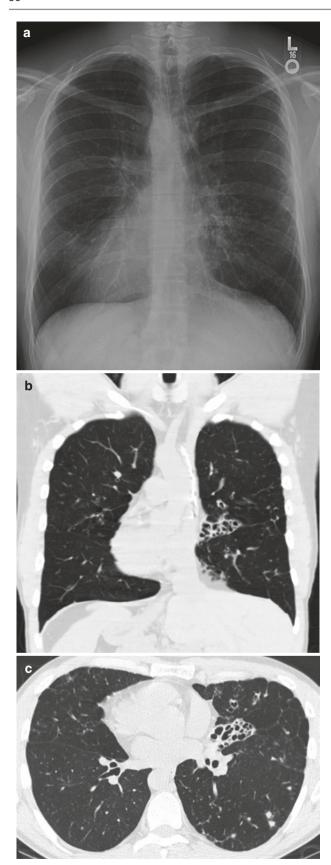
Kartagener's syndrome. (a) Frontal chest radiograph shows situs inversus and bronchiectatic changes in the left parahilar lung. (b, c) Coronal and axial CT images confirm the radiographic findings
